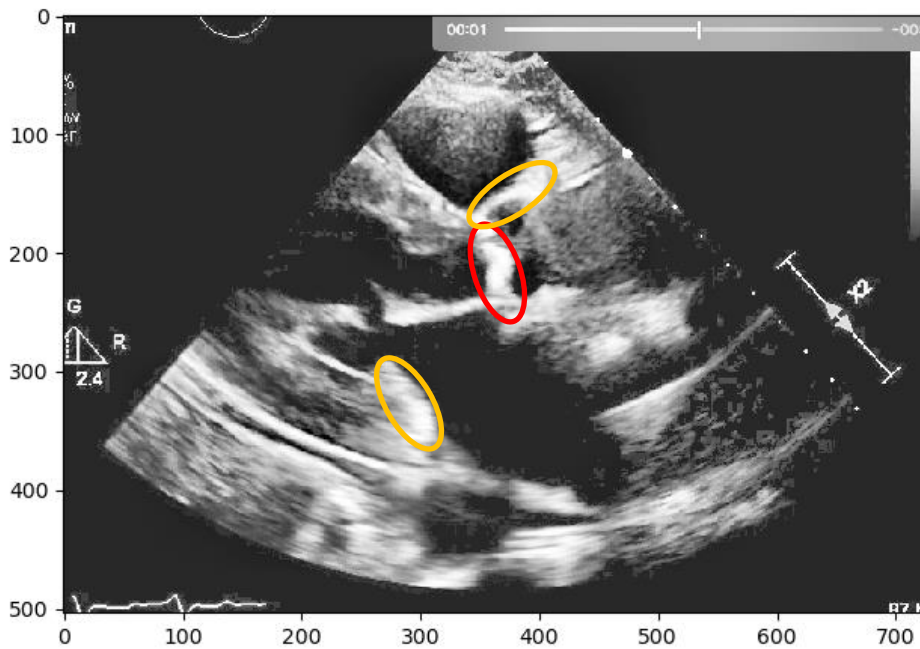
Echocardiography image with CLAHE
